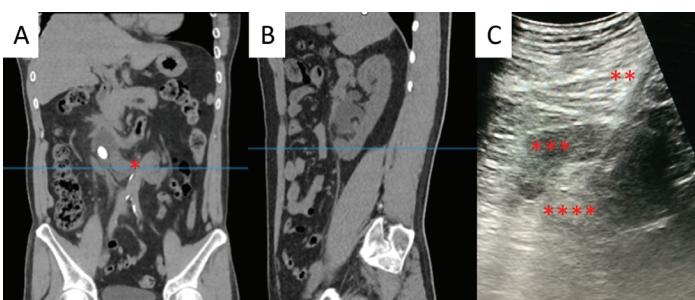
Superior pole access for horseshoe kidney with an anteriorly placed renal pelvis and stone. Isthmus (*) is visible in midline. Horseshoe kidney in coronal (A) and sagittal (B) reconstructions. C, Ultrasound-guided access into upper pole. The access sheath () can be seen traversing the renal parenchyma (*) into the collecting system ().
